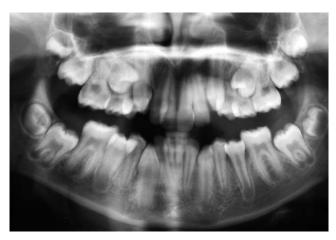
Panoramic radiographic section that was attached to the e-mail survey. The area of the condyles had been omitted intentionally in order to force the clinicians to concentrate their diagnosis on the dentoalveolar area.
